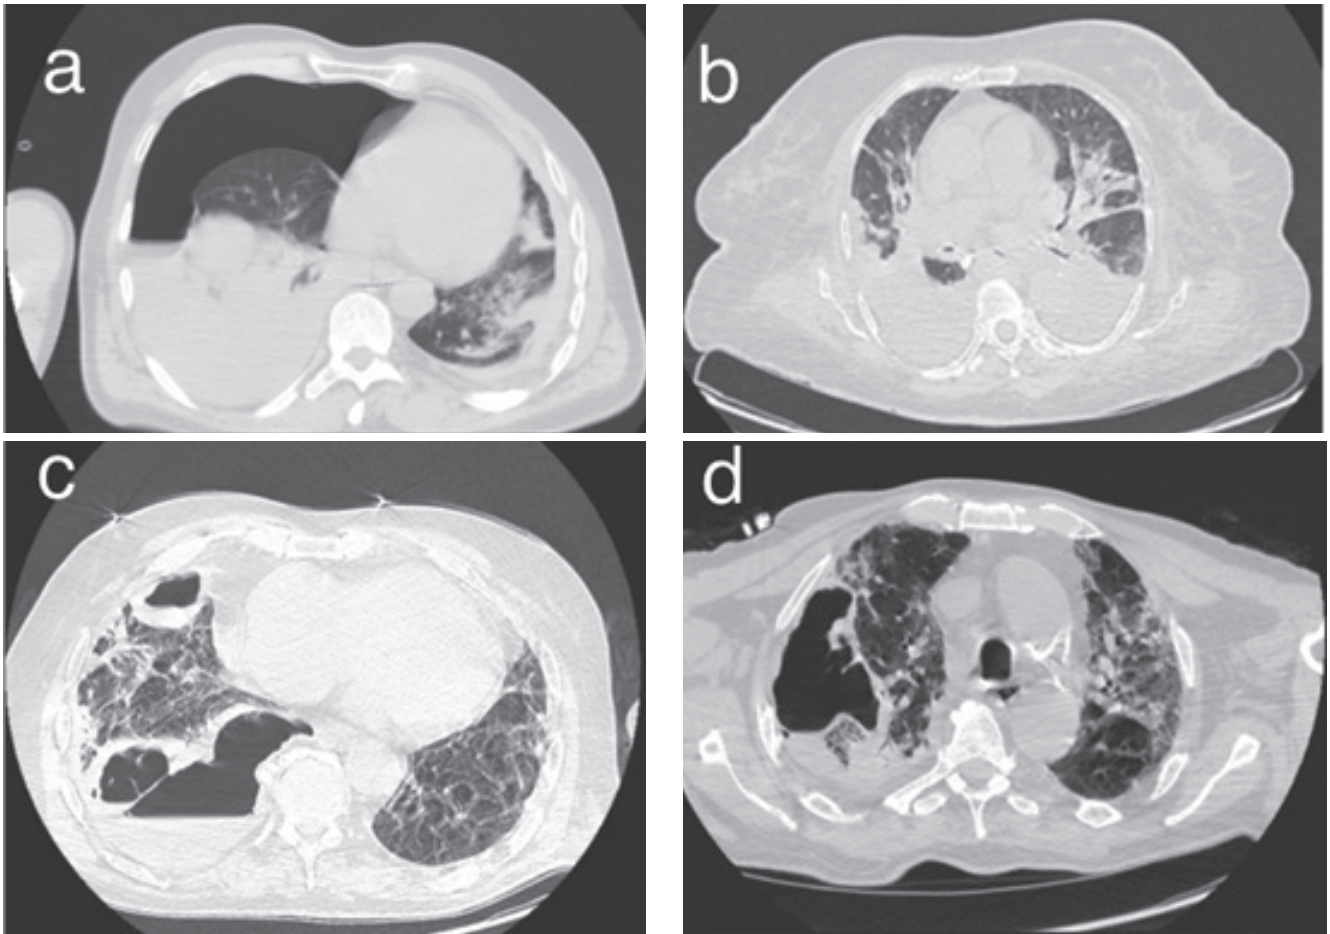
CT imaging in COVID-19 patients: a) right hemopneumothorax; b) bilateral pleural effusion; c), d) right pneumothorax.
